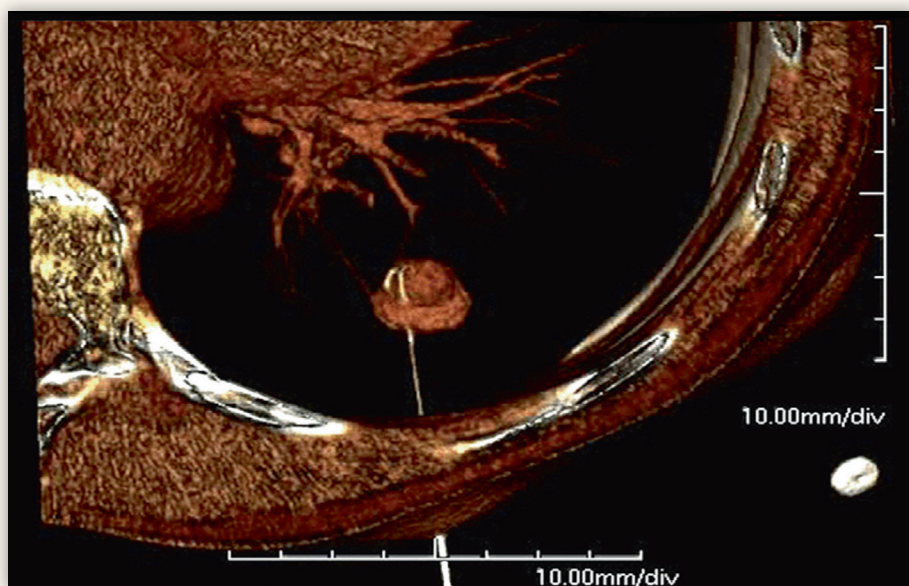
Different stages of CT-guided percutaneous hookwire localization. For demonstration purposes of one of the largest nodules was chosen. 3D reconstruction.
